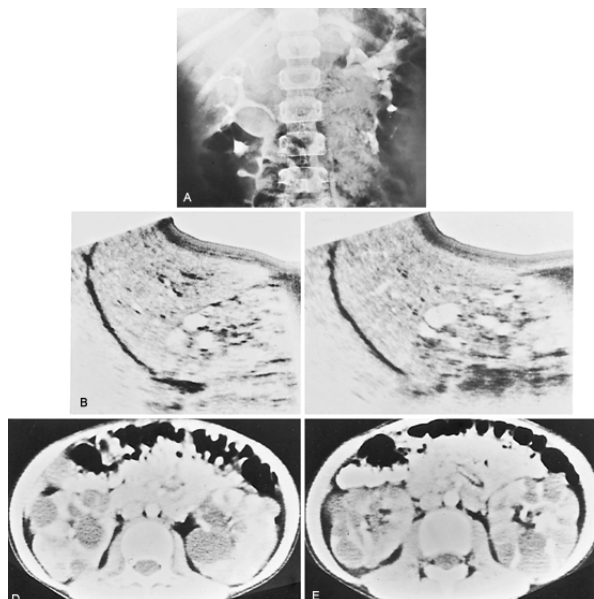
Tuberous sclerosis in a 10-year-old boy whose two brothers and mother were also affected. A: Intravenous pyelogram (IVP) reveals distortion of the collecting systems bilaterally. The splaying of the calyces could be secondary to either cysts or hamartomas. B, C: Renal ultrasonography reveals multiple cysts in both kidneys. D, E: Enhanced computed tomography reveals bilateral multiple renal cysts but no hamartomas. The presence of cysts can precede the presence of hamartomas. He had a seizure disorder, hypertension, and facial adenoma sebaceum. These radiologic findings in such a patient are typical for the TSC_2 - PKD_1 contiguous gene syndrome.
